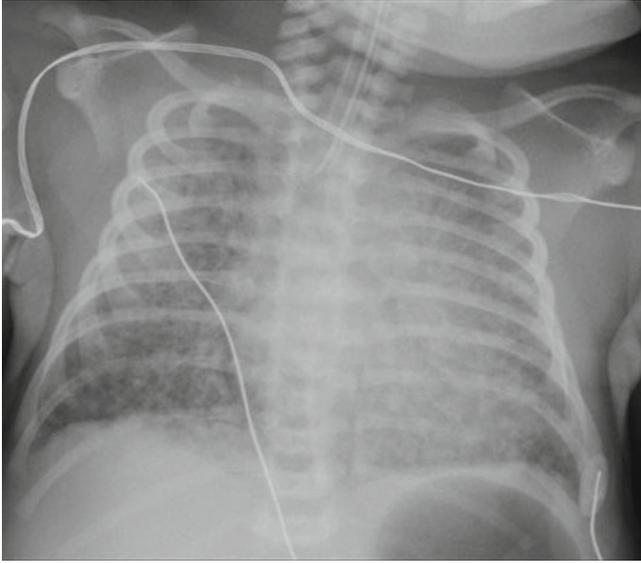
Meconium aspiration. Diffuse, bilateral patchy opacities representing atelectasis and consolidation are seen on this chest radiograph. Note that the patient is intubated and that the heart is mildly enlarged
